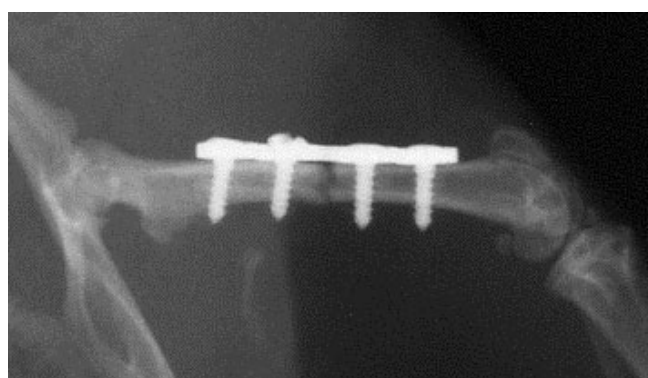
Radiograph of fractured femur.
